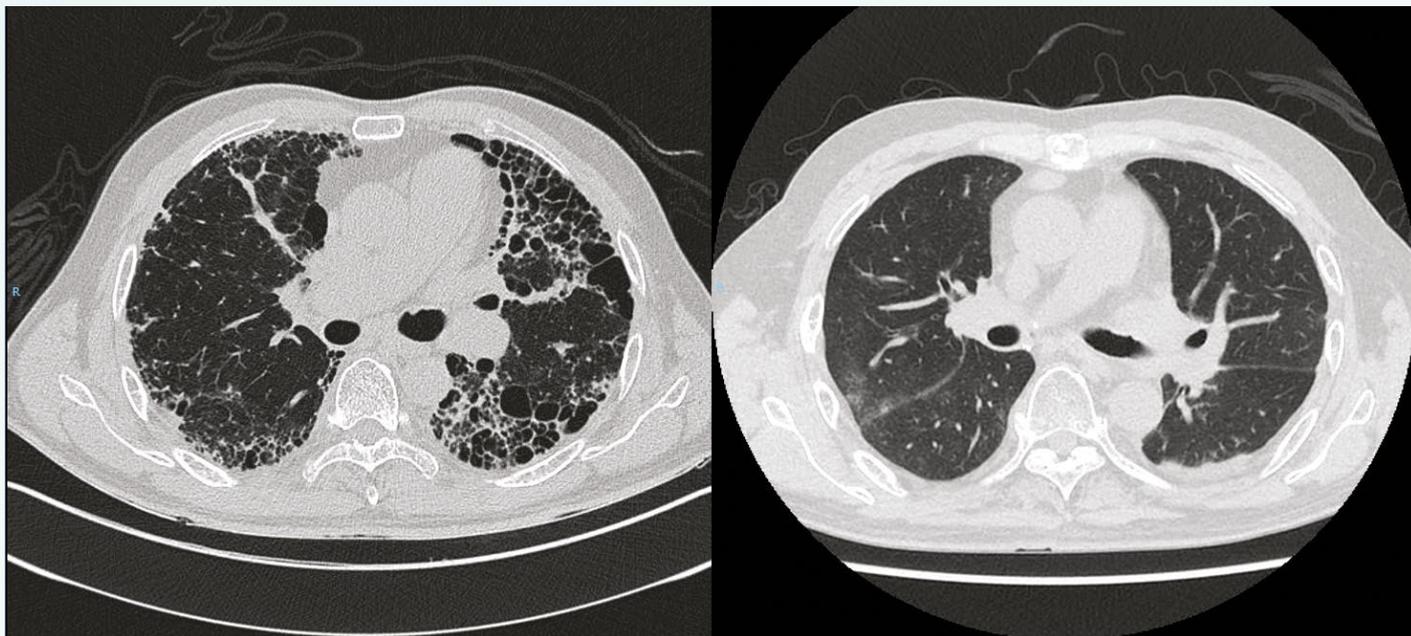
CT thorax of a patient with underlying idiopathic pulmonary fibrosis pre (left) and post (right) lung transplantation
